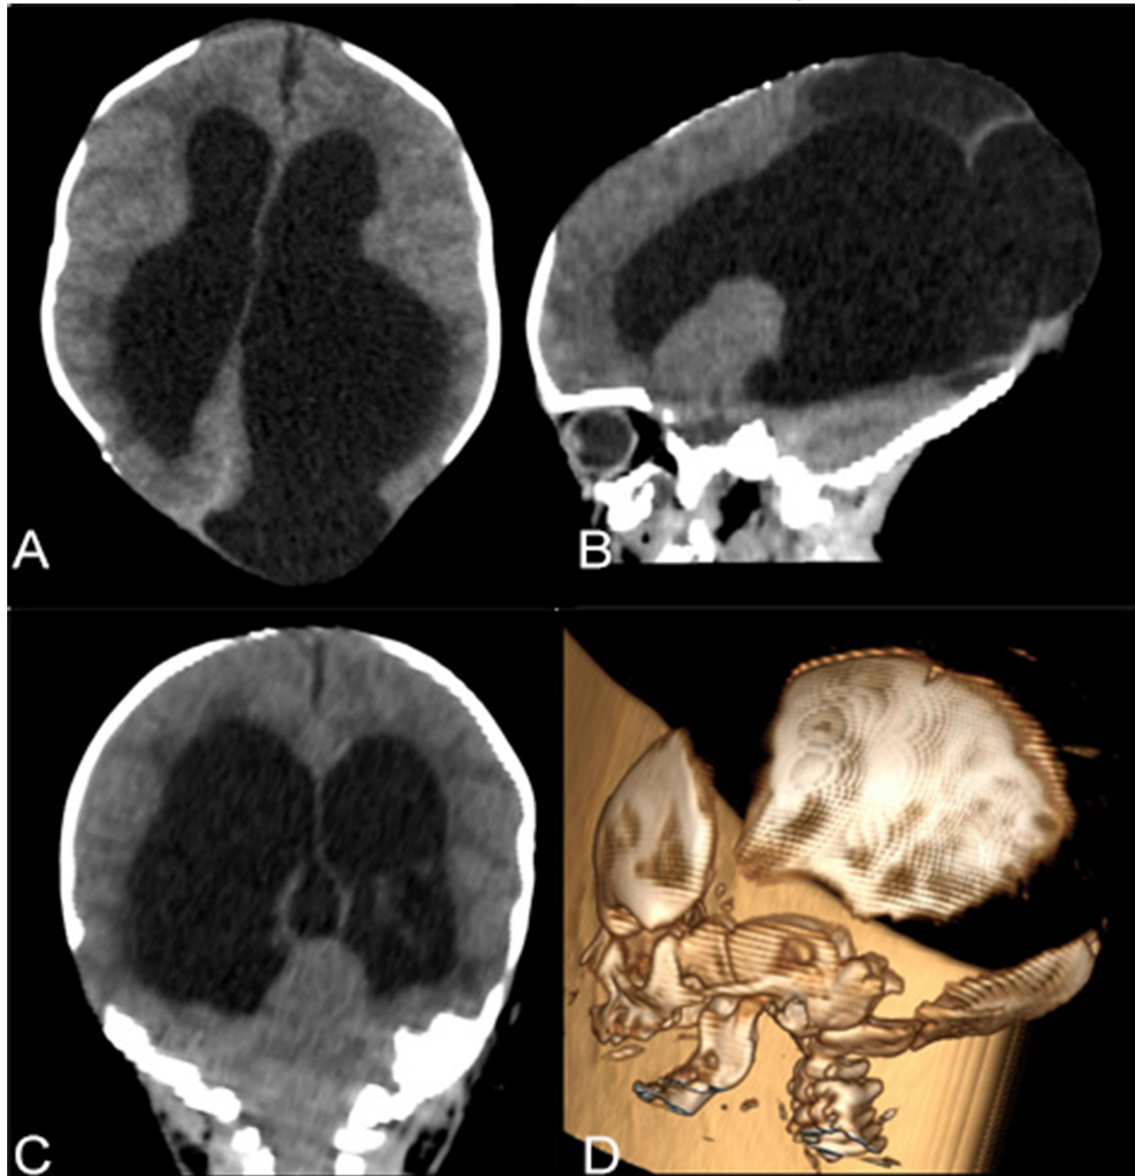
A. Axial section brain CT. Colpocephaly and retraction of the left occipital horn. B. Sagittal section brain CT. Absence of the cranial table in the occipito-parietal region, being more evident on the left side; through this defect is visualized the formation of an encephalocele. C. Coronal section brain CT. Dilatation of the lateral ventricles and third ventricle. D. 3D reconstruction. "Lemon Skull" appearance due to the increase in the anteroposterior diameter with the absence of the cranial table in the occipito-parietal region.
